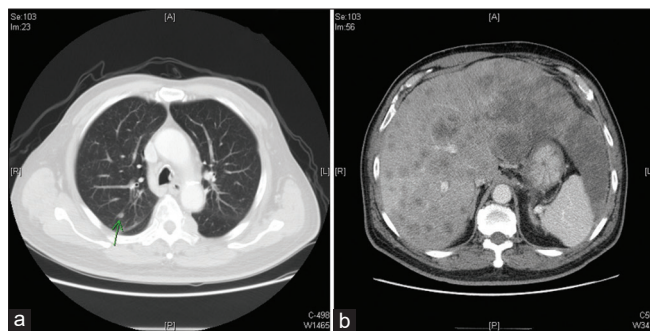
(a and b) Initial computed tomography image on August 21, 2020. Multiple liver metastasis was seen
